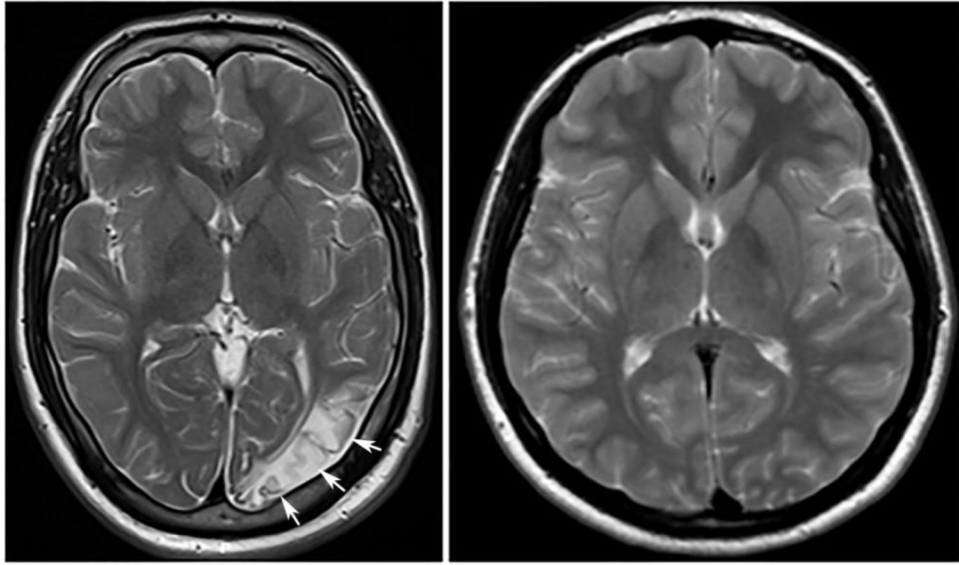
MRI of index case
